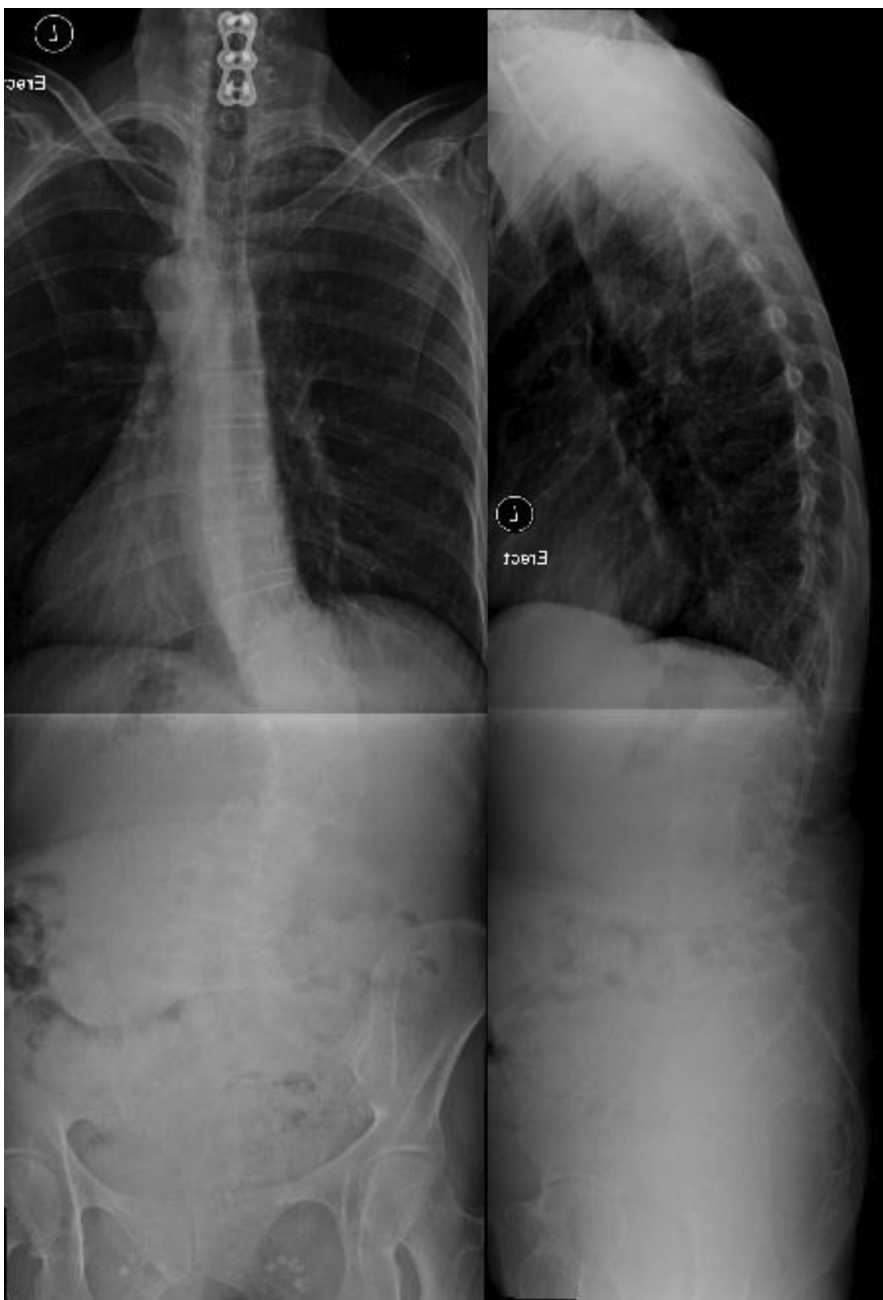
Preoperative anteroposterior/lateral erect radiographs depicting poor bone quality in a 52-year-old woman with adult degenerative scoliosis. The presence of osteoporotic bone makes it difficult to visualize the spinal bony anatomy.
